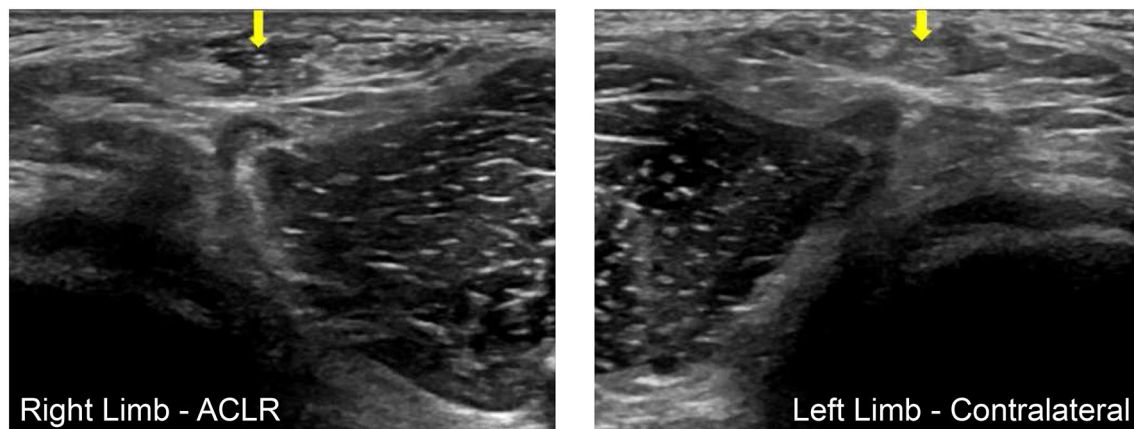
Sample ultrasound image confirming no regeneration of tendon-like tissue in the semitendinosus tendon space at the knee crease of the anterior cruciate ligament reconstructed (ACLR) limb. Only 2
